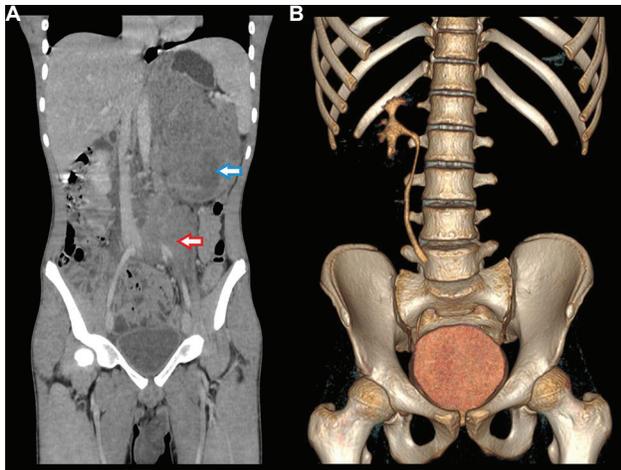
(A) Contrast enhanced computed tomography of abdomen showing a left renal mass replacing the whole kidney (blue arrow) with retroperitoneal lymphadenopathy encasing left iliac vessels and abdominal aorta (red arrow) and (B) non-functioning left kidney on CT intravenous urography.
